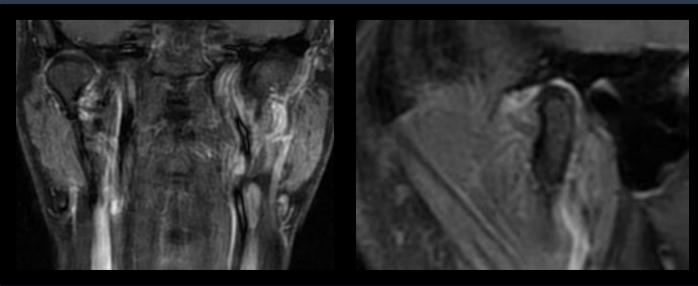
MRI image showed intact articular disc surface with no signs of perforation, proving the fragment definitely fell from the roof of the mandibular fossa into the superior joint space.
